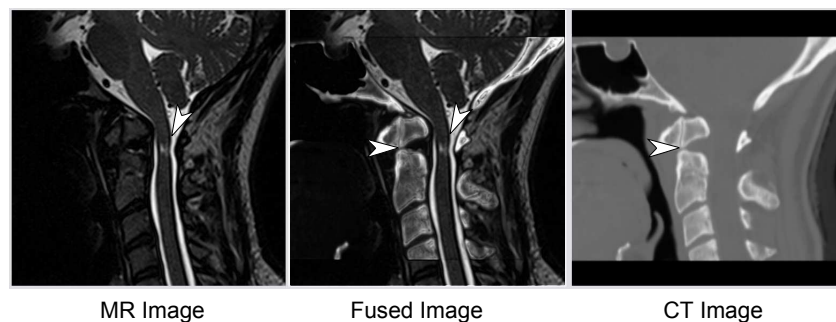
Image of an abnormal vertebrae and cord damage: left - in the MR the cord damage is easily visible; center - the fused image: the cord damage and the abnormal vertebral body can be seen clearly; right - the CT image shows the abnormal vertebrae.
